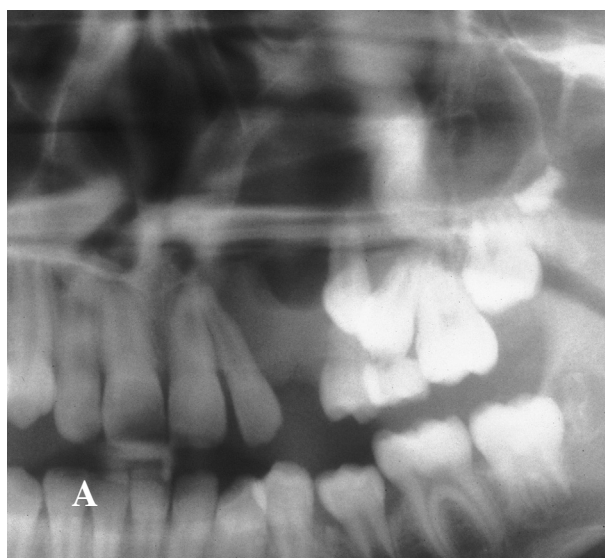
A unicystic ameloblastoma, intraluminal type, of the maxilla. A. Panoramic radiograph shows a unilocular radiolucency of the left maxilla. B. Curative treatment involves an enucleation and curettage of the tumor.
